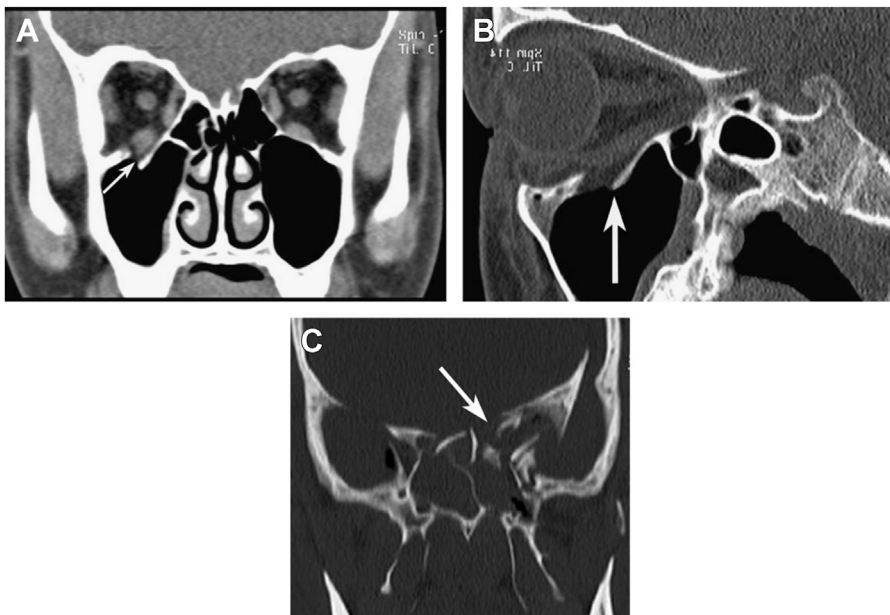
Orbital fractures. (A) Coronal noncontrast-enhanced CT scan shows a depressed floor of orbit fracture with rounding of inferior rectus muscle indicating likely muscle entrapment (arrow). (B) Oblique sagittal bone window CT scan shows a depressed floor of orbit fracture (arrow). (C) Coronal bone window CT scan shows comminuted orbital fractures surrounding left optic canal with potential optic nerve impingement (arrow). (Reproduced from Goh PS, Gi MT, Charlton A, et al. Review of orbital imaging. *Eur J Radiol* 2008;66(3):387–95. <https://doi.org/10.1016/j.ejrad.2008.03.031>; and Data from Matic DB, Tse R, Banerjee A, et al. Rounding of the inferior rectus muscle as a predictor of enophthalmos in orbital floor fractures. *J Craniofac Surg* 2007;18(1):127–32. <https://doi.org/10.1097/SCS.0b013e31802ccdc8>; and Gabrick K, Smetona J, Iyengar R, et al. Radiographic predictors of FACE-Q outcomes following non-operative orbital floor fracture management. *J Craniofac Surg* 2020;31(4):e388–91. <https://doi.org/10.1097/SCS.00000000000006356>.)
